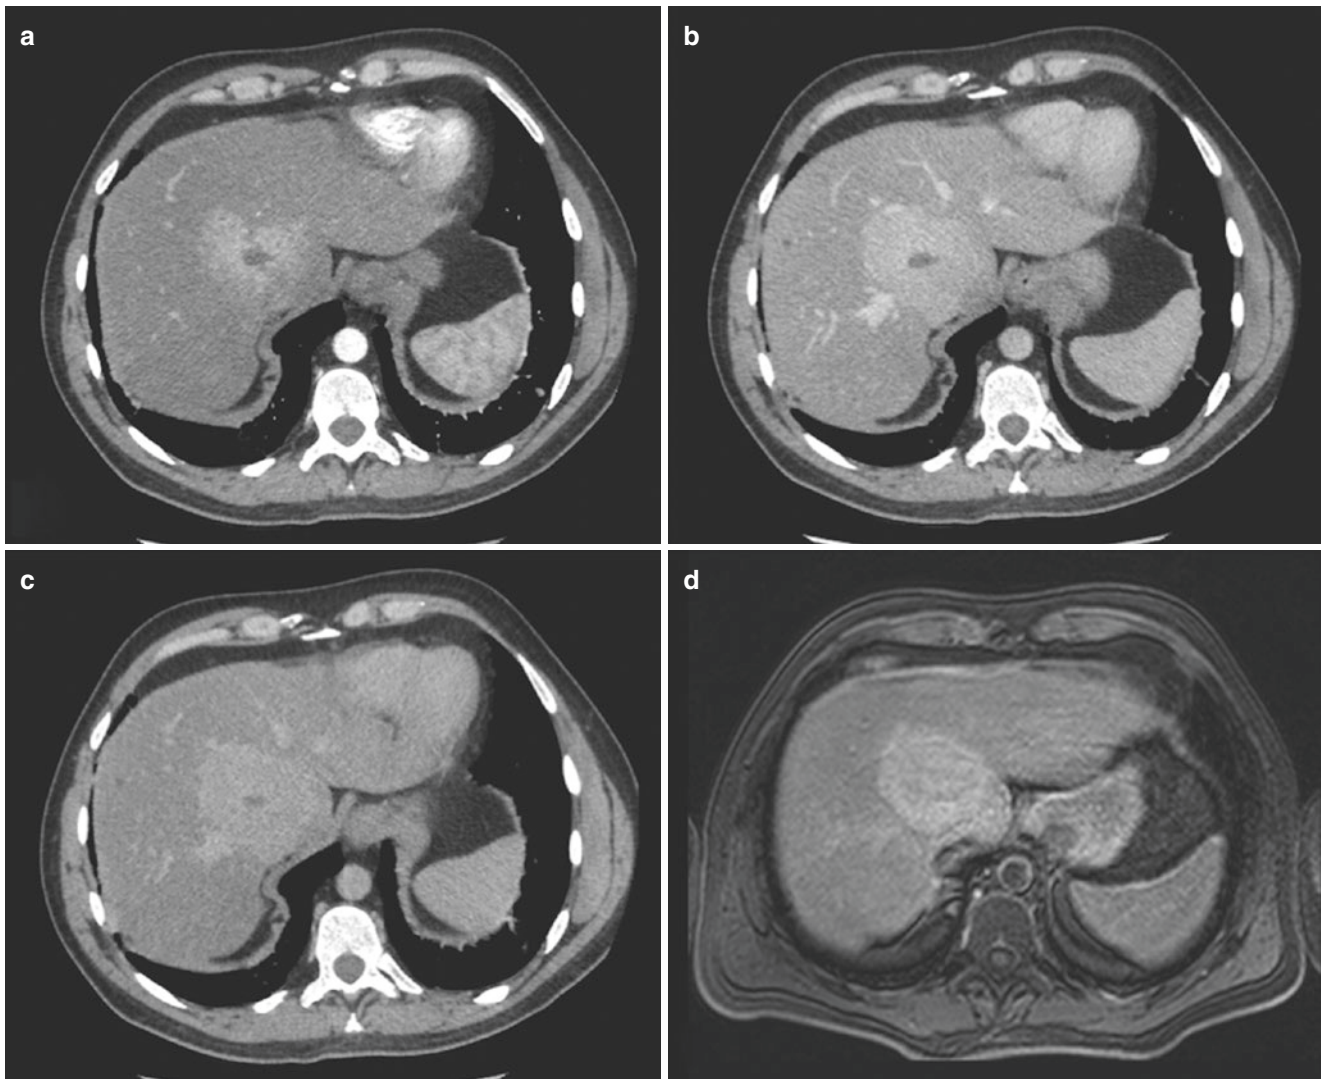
Liver FNH. Arterial phase (a) shows a round lesion with rapid contrast enhancement, and a central scar can be observed. The lesion is hyper-attenuating compared to the liver parenchyma on portal (b) and equilibrium phase (c). MR image acquired after 120 min after
